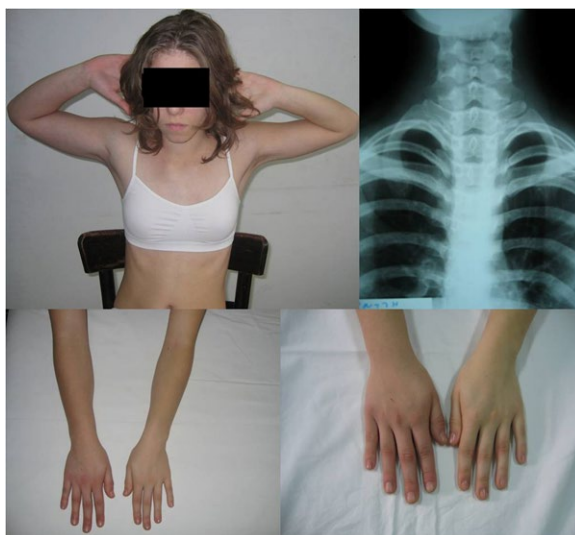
A 13-year-old girl demonstrated the typical findings of vascular thoracic outlet syndrome on the right side. Abduction of the arms to 90 degrees in external rotation, in about one minute after the test, caused pain, cyanosis and a feeling of cooler and swollen localized in the whole right upper extremity. The radiograph indicated rudimentary short cervical ribs on both sides of the seventh cervical vertebra.
